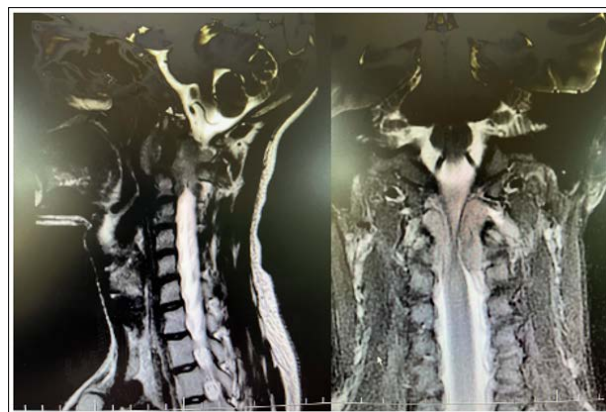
Which shows MRI T2 sequences of the craniovertebral junction in sagittal and coronal planes (A and B respectively) demonstrates the extreme compression of the upper cervical cord secondary to a mass lesion canal posteriorly and medially
